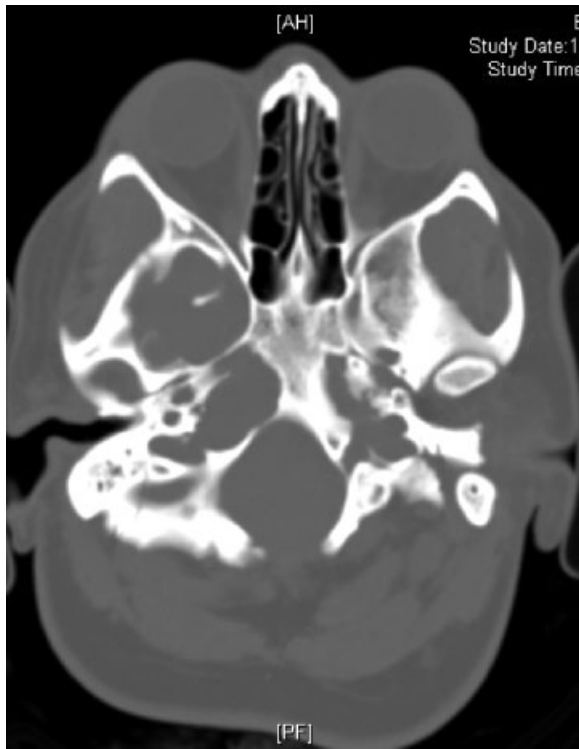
A CT of the head demonstrating a large lesion in the right petrous apex (case 2).
